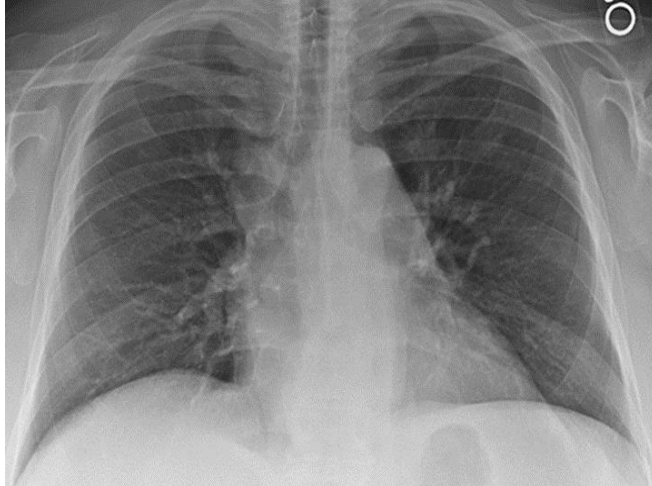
Frontal chest radiography performed 2 years prior to presentation.
